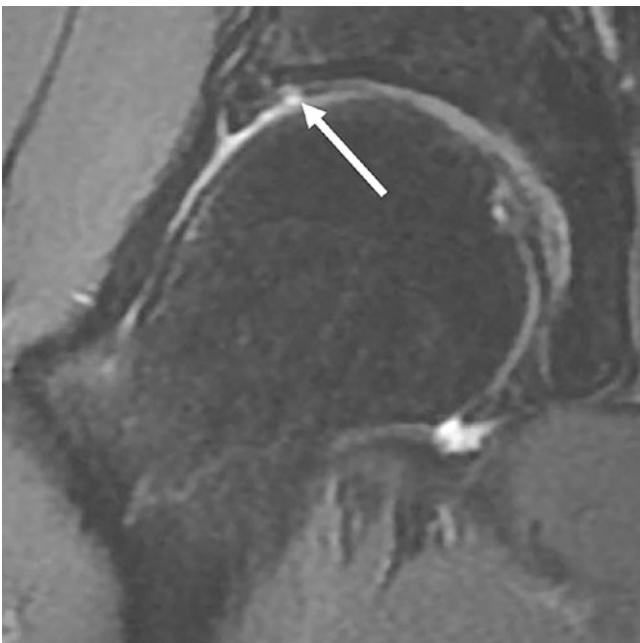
Coronal T2 fat-suppressed MR image in a 34-year-old man shows a focal cartilage defect near the labral base (arrow). Additionally, adjacent linear low signal may represent cartilage delamination. At arthroscopy, this was confirmed as delamination
